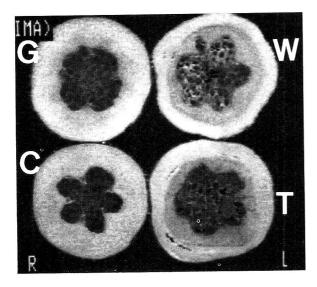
X-ray CT images of different samples of papaya fruit: G:unripe fruit; C:control (ripe or normal fruit); W:wrapped treated fruit; and T:thermally injured fruit.
